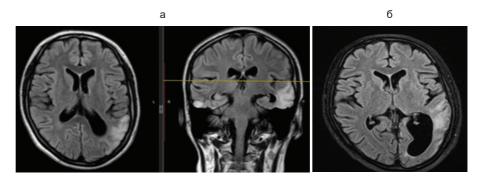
MRI of the brain: a) from October 2019; b) from October 2022
